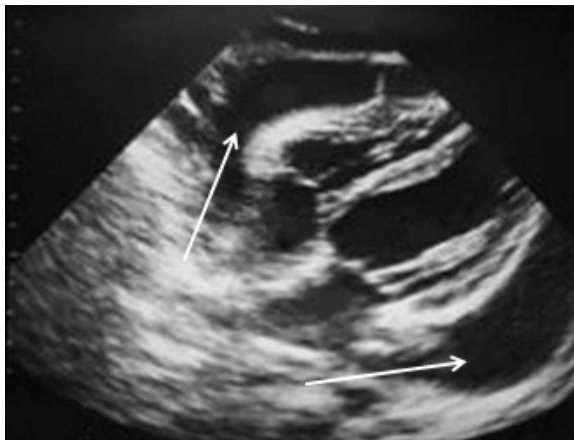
Echocardiography. Arrows show significant pericardial effusion
